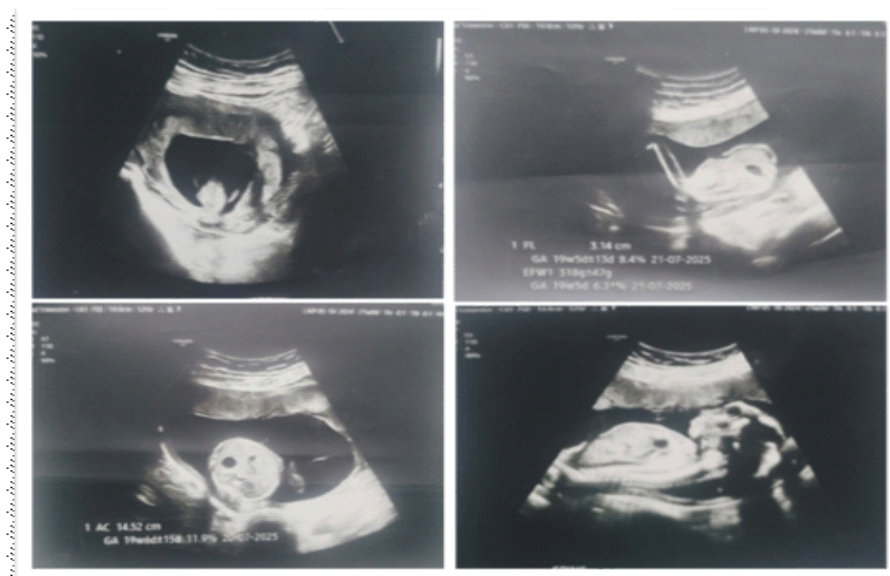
Image source Ultrasonographic images of patient
